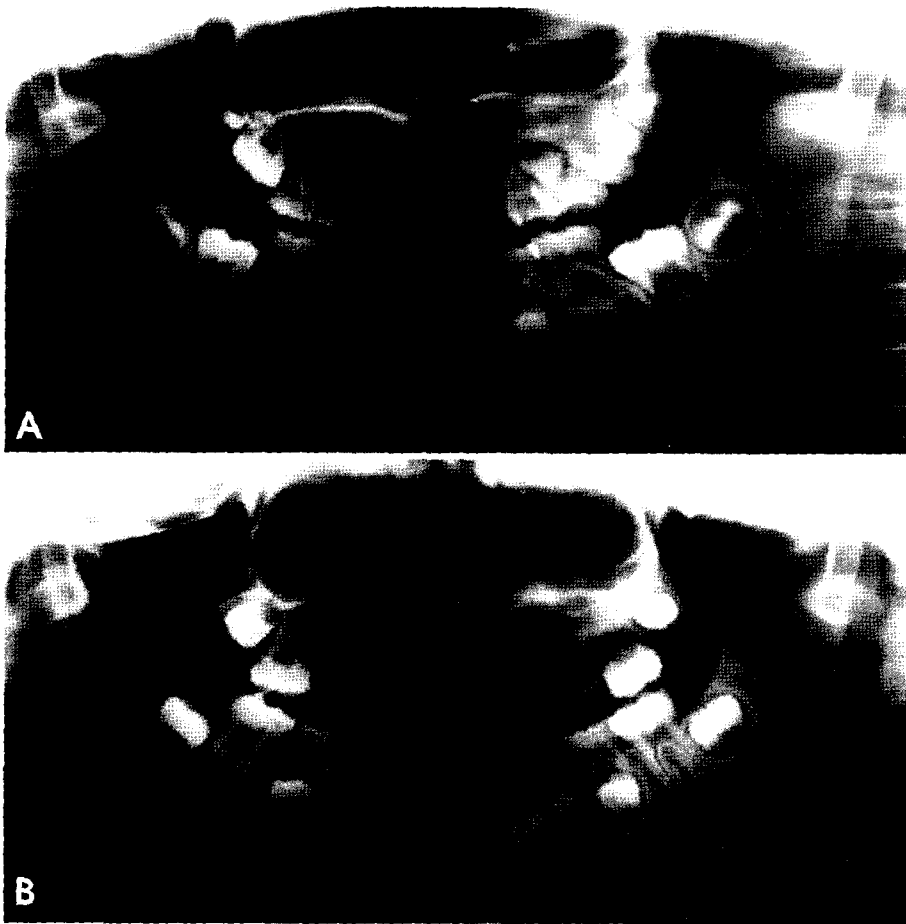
Panoramic radiographs of the patient at age 6 (A), and 9 (B) showing multiple reduction in height of maxillary alveolar ridge, delayed eruption of maxillary and mandibular teeth, and multiple missing teeth.
